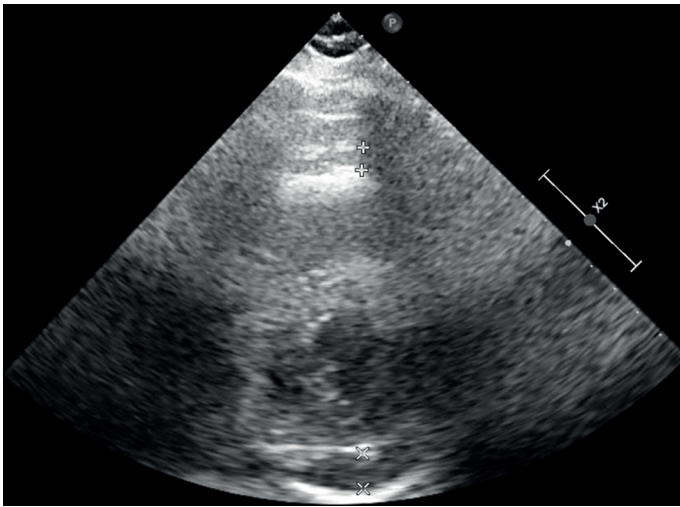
Echocardiography image of patient's pericardial effusion.
